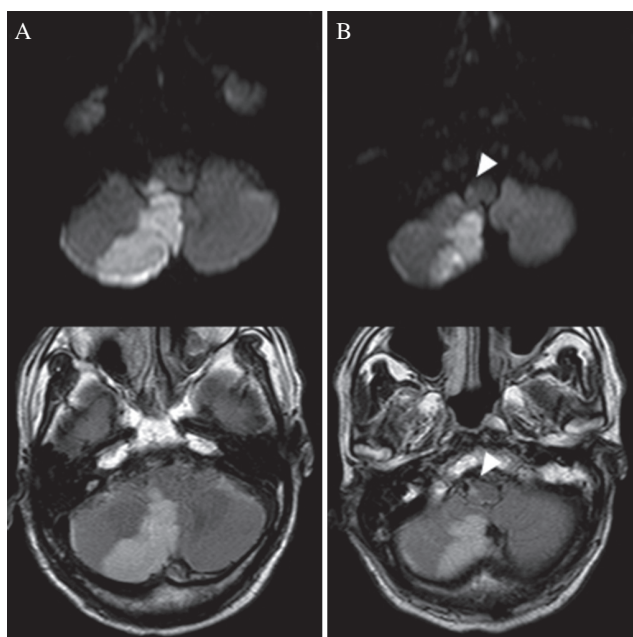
Postoperative magnetic resonance imaging (upper: diffusion-weighted imaging, lower: fluid-attenuated inversion recovery imaging) reveals the right inferomedial cerebellar infarction and lateral medullary infarction (A) extending to the ventral side (B, white arrowhead).
